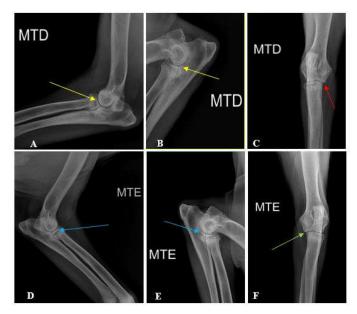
Male, 8 months old. A to F - Radiographies of both right and left affected elbow joints. Neutral positions on medial-lateral images of right (A) and left elbows (D). Stress positions on medial-lateral images of left (B) and right elbows (E). Cranial-caudal radiographies views of the right and left elbows (C and F, respectively). Slight joint incongruence of both elbows represented by the yellow arrows in A and B (right elbow) and D and E (left elbow). In C and E there are medial coronoid processes anatomical defects in the right ulna (red arrow) and left ulna (green arrow). MTD = right thoracic limb; MTE = left thoracic limb
